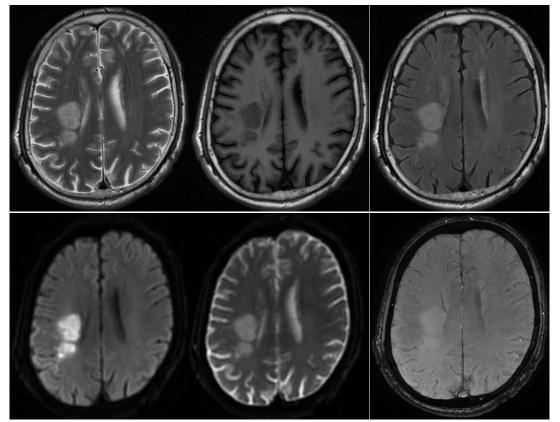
MRI image of brain edema due to acute cerebral infarction
